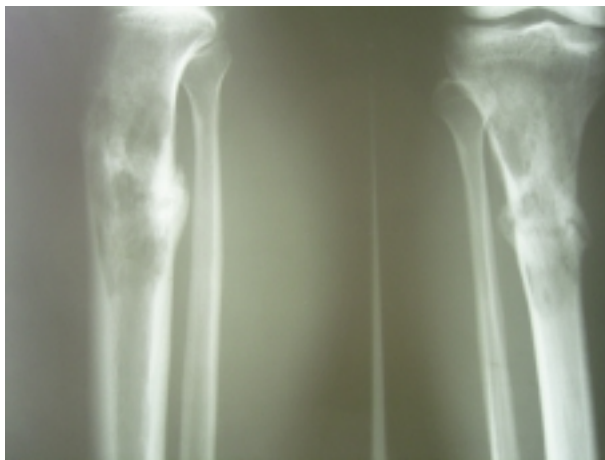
Oblique radiograph of the left tibia demonstrating an osteolytic lesion with moth-eaten appearance and prominent periosteal reaction.
